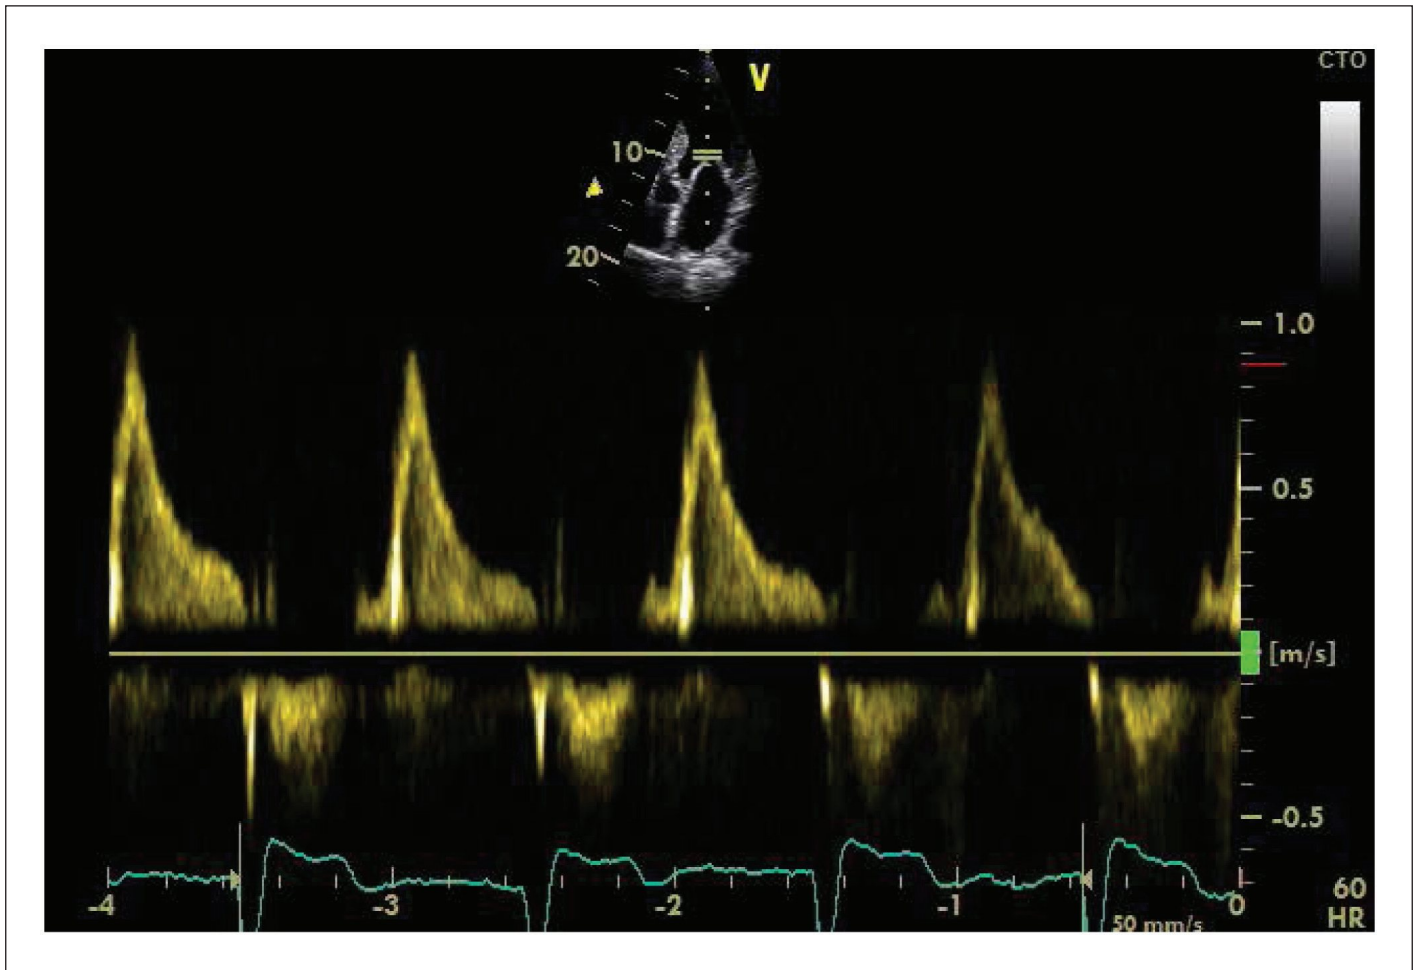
Transmitral pulsed-wave Doppler imaging after isoproterenol infusion, showing the absence of A waves.
